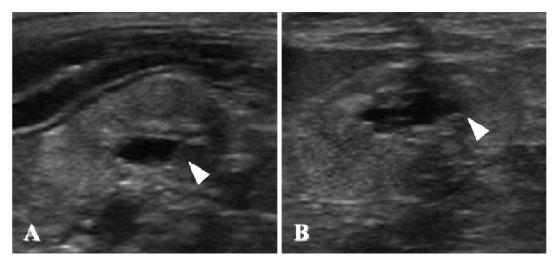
Kidney ultrasound images from a miniature Poodle with renal dysplasia. Both right (A) and left (B) kidneys were small, asymmetrical, hyperechoic and irregular in shape. The renal cortex and medulla was diffusely hyperechoic and there is poor corticomedullary definition. Bilateral pelvic dilation was also observed (arrowheads). Renal length was 2.1cm (A) and 2.4cm (B), respectively.
